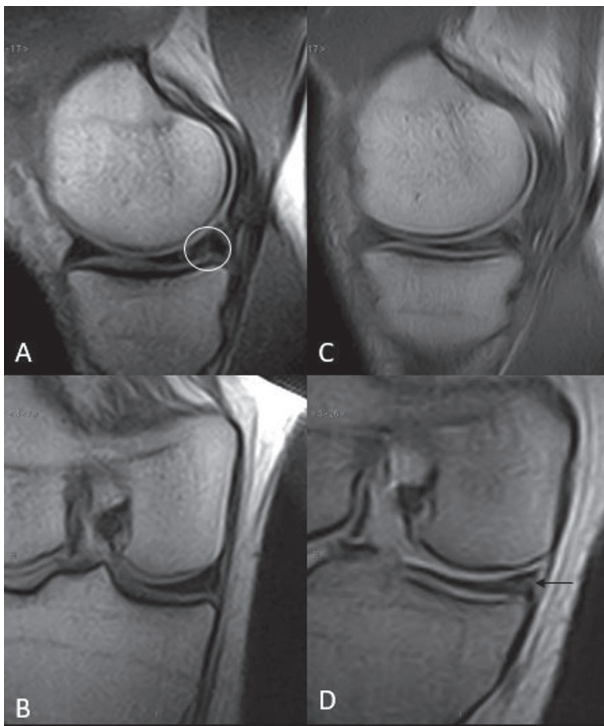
Sagittal and coronal MRI images of the knee in standard supine (A, B) and weight-bearing upright position (C, D). Note how the posterior horn meniscal tear (white circle) becomes more evident under weigh-bearing (black arrow), finding consistent with an unstable tear
